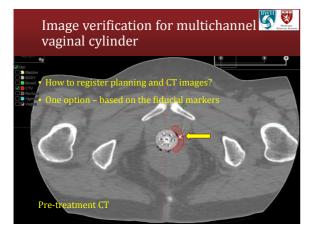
Image verification using CT and MRI
